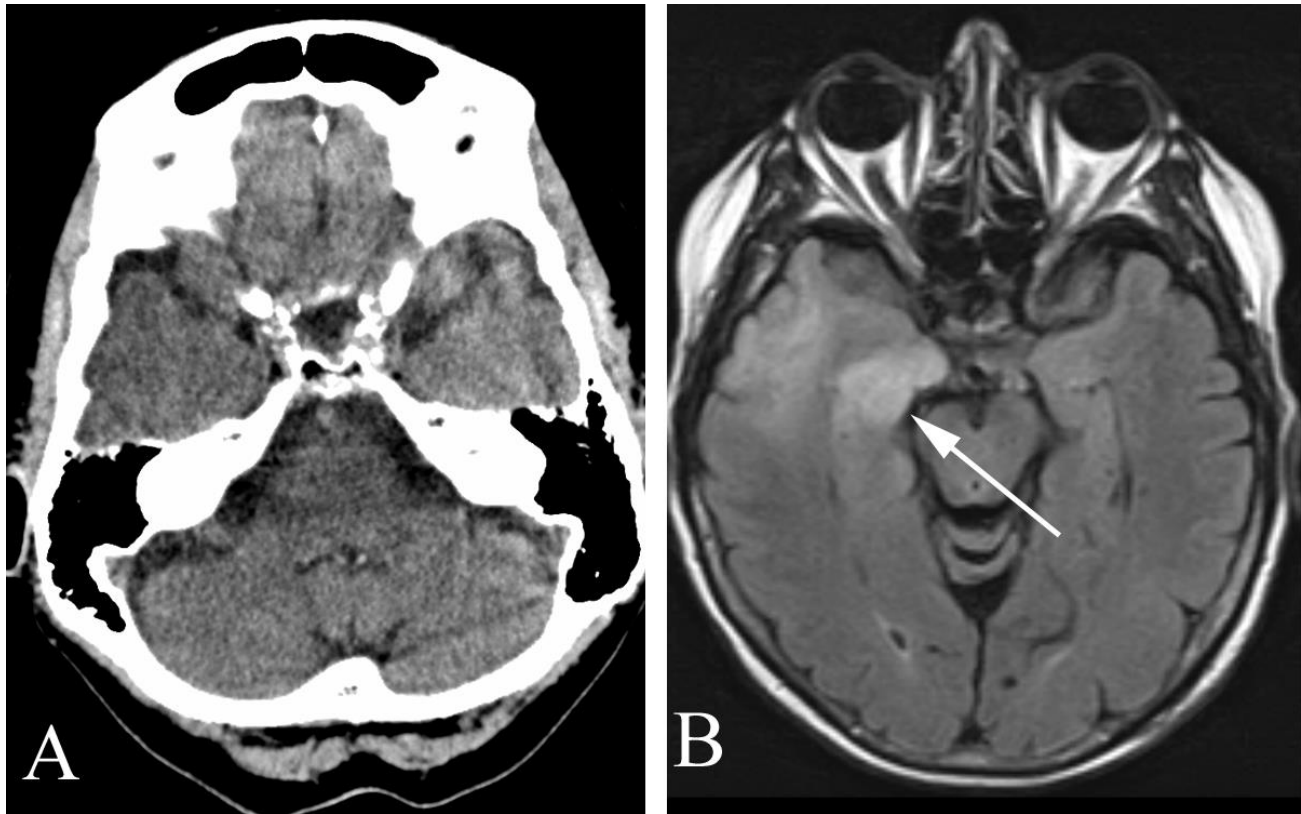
Temporal lobe astrocytoma in a 77 year old woman who experienced syncope. A. Nonenhanced axial CT study shows no abnormality. B. Axial FLAIR MR image demonstrates increased signal intensity along the left temporal lobe (arrow). Astrocytoma was found on biopsy.
